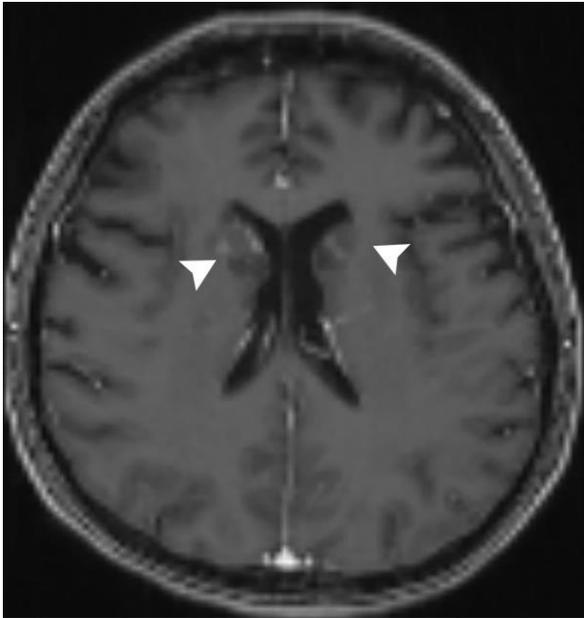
Brain MRI, axial post-contrast T1-weighted image. Punctate gadolinium enhancement in some of the lesions (arrowheads).
